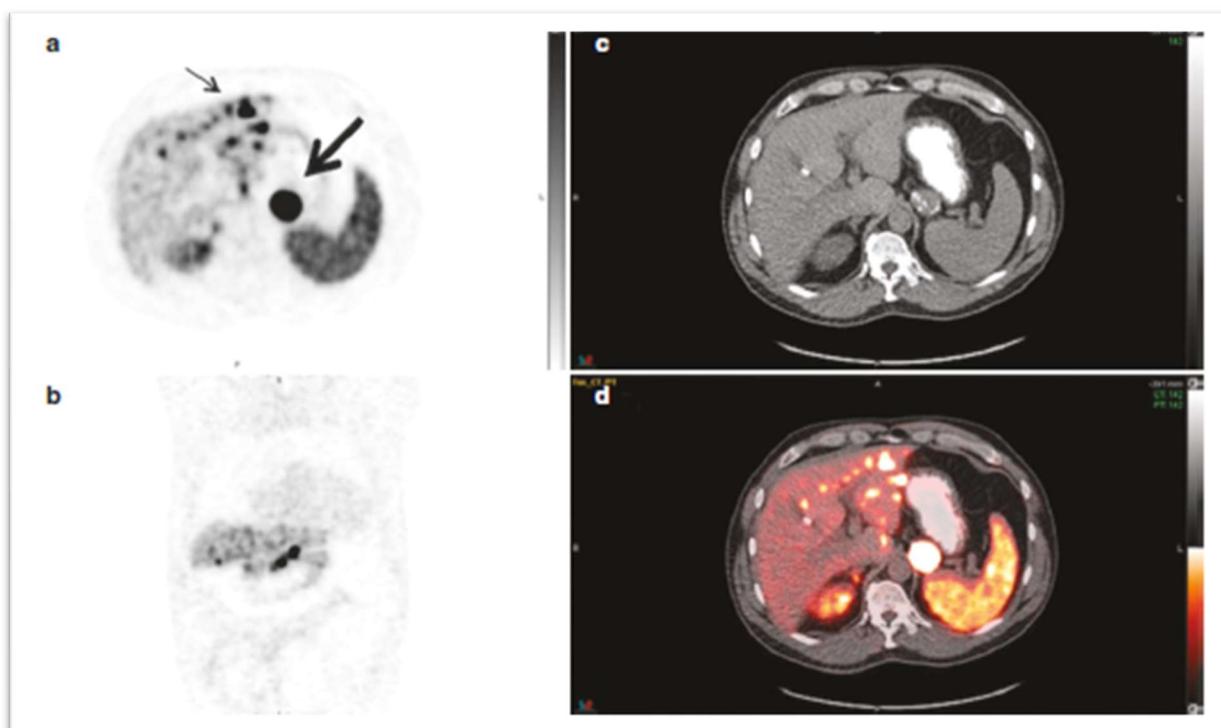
The staging of tumour using ^{68}Ga -DOTATE PET/CT. Imaging of somatostatin receptor-expressing carcinoid tumour deposits using a PET scan (a, b) and relate the localization of sites of radiopharmaceutical uptake to anatomic sites indicated by the accompanying CT (c) and depicted on fused PET and CT images (d).
